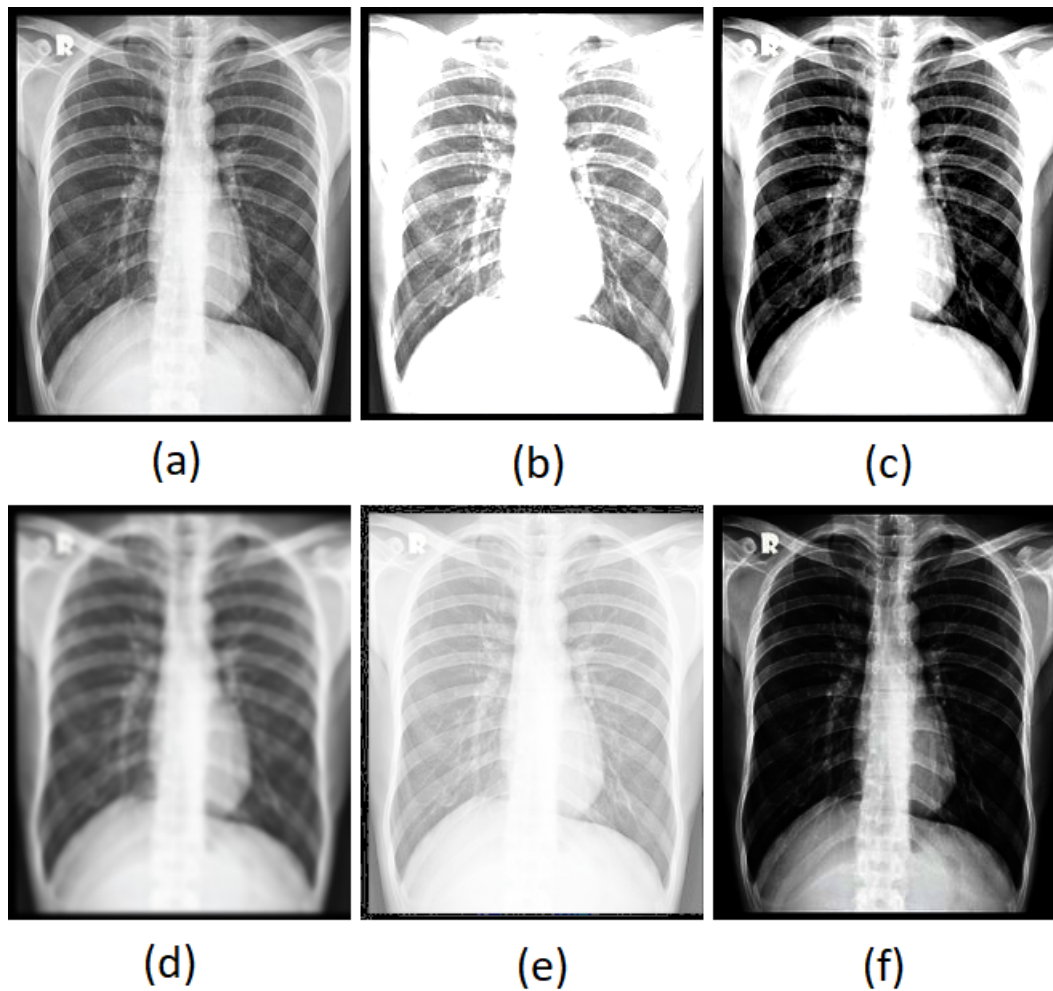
Example of pixel-level transformations applied to a chest x-ray image. Respectively: (a) original image (b) brightness (c) contrast (d) blur (e) light gamma correction (f) dark gamma correction
